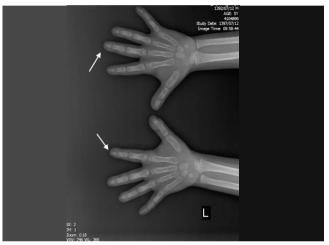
The X-ray of the boy's hands shows shortened first through fourth distal phalanges.
